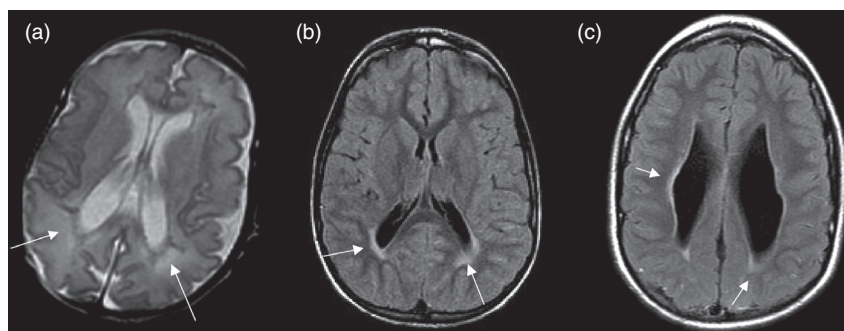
Diffuse PVL (high intensities – arrows) on (a) near-term axial T2 and (b,c) older infant axial FLAIR MRI.
